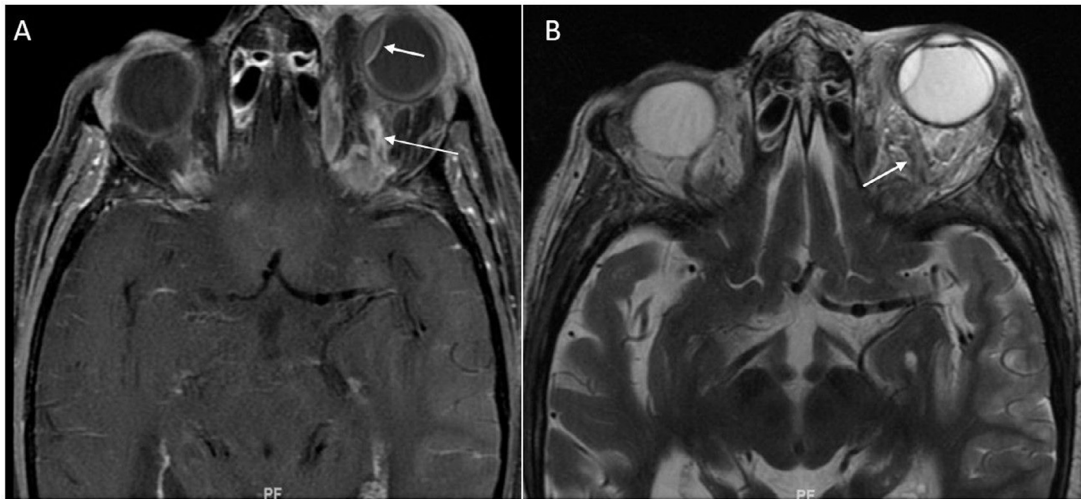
Contrast enhanced magnetic resonance imaging. (A) Axial T1-weighted image of the orbits showing the presence of a thrombus in the left superior ophthalmic vein (white long arrow) and choroidal detachment with underlying hemorrhage (short white arrow). (B) Axial T2-weighted image of the orbits showing significant edema of the intra- and extraconal fat and periorbital edema with proptosis of the left eye. The superior ophthalmic vein is enlarged and thrombosed (white arrow).
